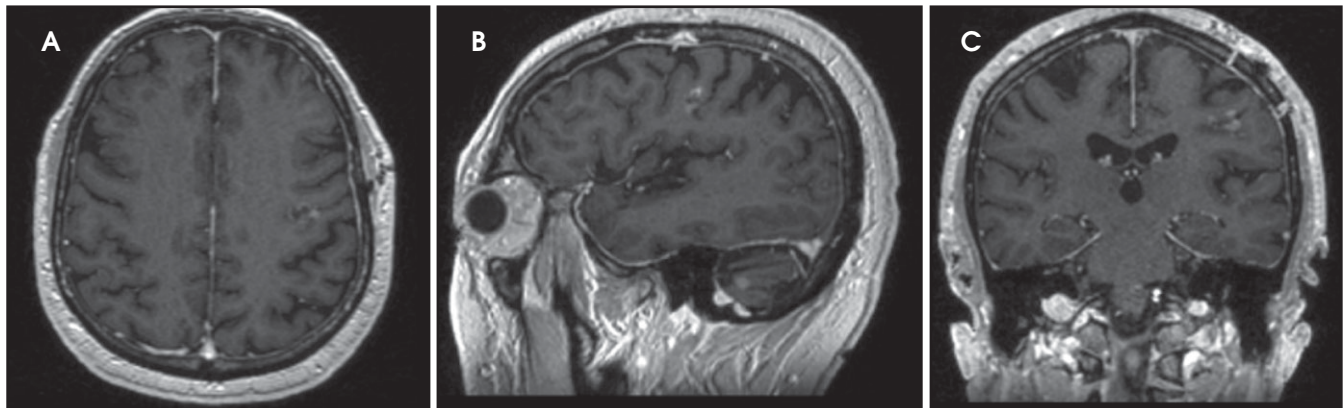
T1 MRI images with contrast completed ~1 month after Gamma Knife in the (A) axial, (B) coronal, and (C) sagittal views showing a small ring-like area of susceptibility artifact in the subcortical white matter of the left paralytic white matter, but no areas of definite enhancement identified.
